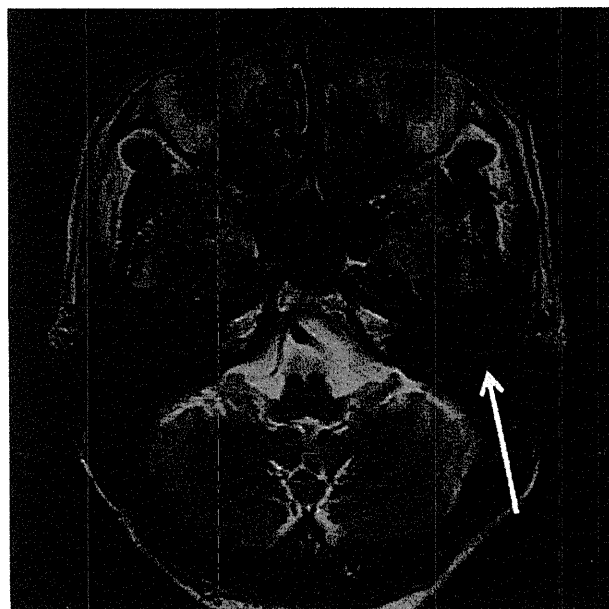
A routine T2-weighted axial image with 5 mm thickness. Cerumen impaction is faintly visualized (arrow).
